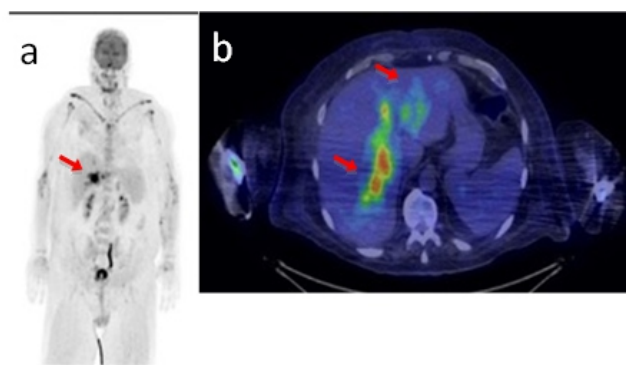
Male, 59 year old with FUO and asthenia. Hepatic biopsy without guide: fibrosis and chronic inflammation, signs of hepatitis. MRI: hepatic interstitial thickening. Fluorine-18-FDG PET/CT: unexpected focal lesions in the VIII-V and II hepatic segments, in the laterocervical and mesenteric lymph-nodes, clavicles, humeri and in the sternum. Second liver biopsy PET guided: address to correct diagnosis of hepatic lymphoma.
